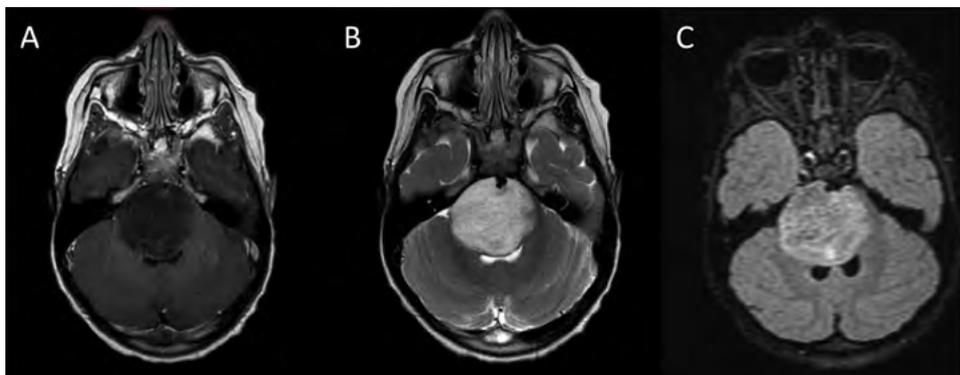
Typical MRI appearance of DIPG: on (A) T1-weighted post-contrast images, (B) T2-weighted images, and (C) FLAIR images; copy from [4].
